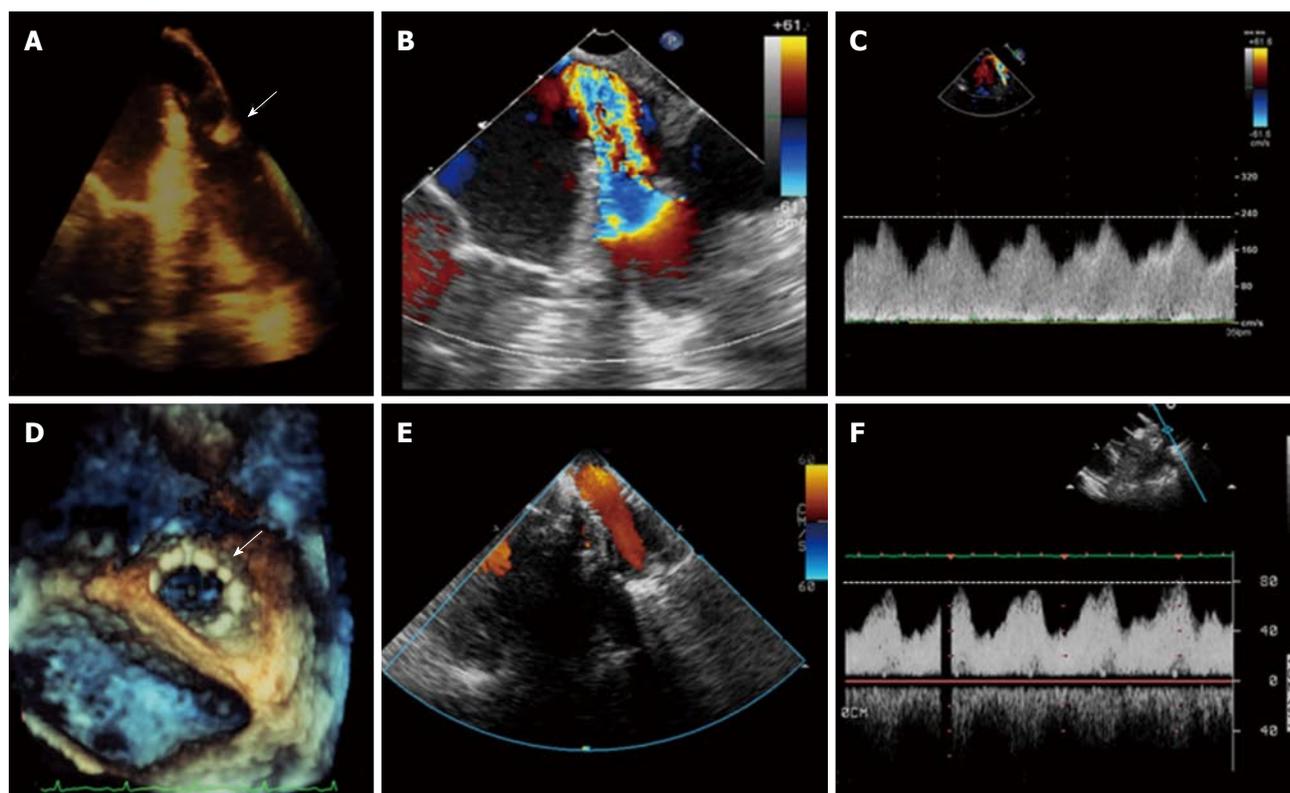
Transesophageal echocardiography of a patient with a recent left lung transplantation and severe congestion in the graft. A: Narrowing in the common trunk of the left PVs at the level of the sutures (arrow). Color Doppler and Continuous Wave Doppler demonstrate turbulent flow (B) and high velocity (C: peak velocity 2.4 m/s; peak gradient 23 mmHg) across the vessel which is consistent with a significant stenosis. A stent was successfully implanted at the level of the stenosis (D: "en face" 3D echo image view; arrow). Laminar flow (E) and normal velocities (F: peak velocity 0.8 m/s; Peak gradient 2.5 mmHg) were seen after the procedure.
